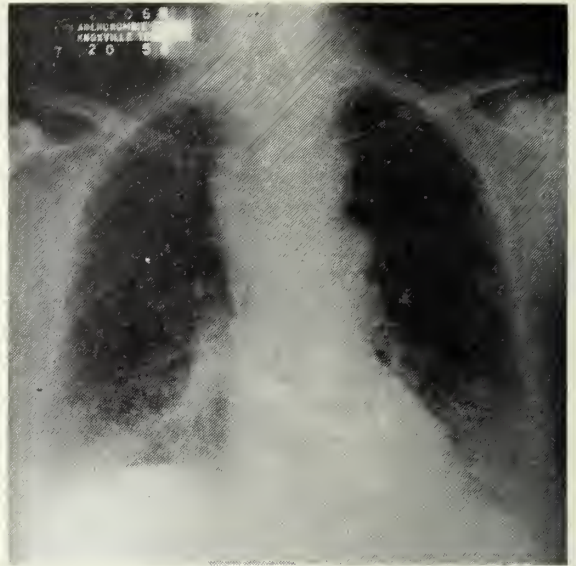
M. N. Preoperative P. A. chest roentgenogram showing intrathoracic goiter extending into superior mediastinum.
